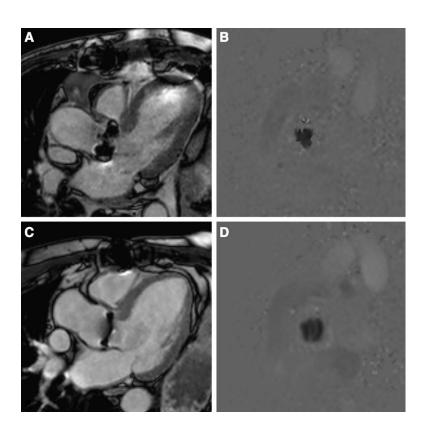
Magnetic resonance imaging flow assessment left ventricular outflow tract steady-state free-precession images (A and C) and in plane phase-contrast images (B and D) of a biological Carpentier-Edwards Perimount and a mechanical St. Jude aortic prosthetic heart valve, respectively. Note the single opening orifice of the biological valve (B) and the 3 opening orifices of the mechanical valve (D).
